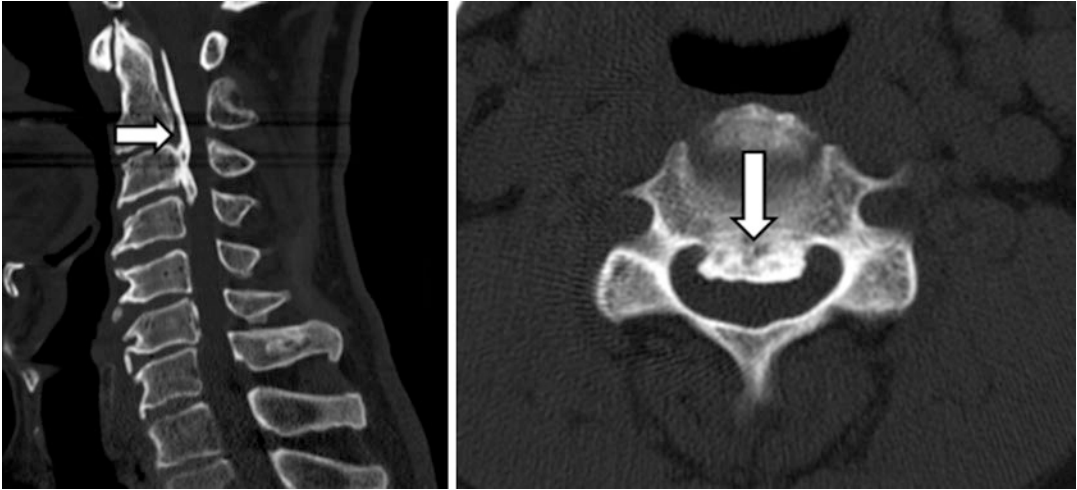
CT demonstrating ossification of the posterior longitudinal ligament (*arrow*) causing canal stenosis and cord compression
